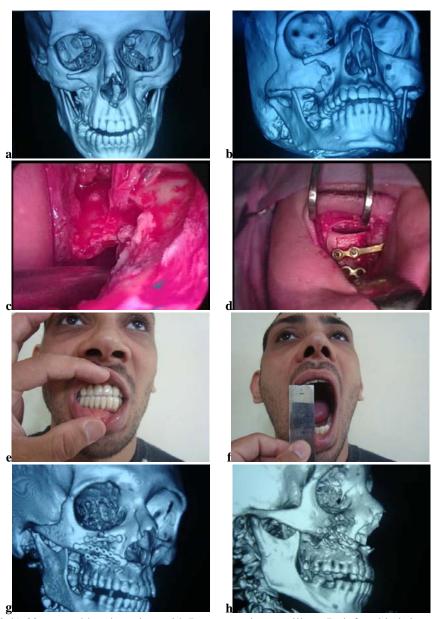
(a& b) 32 years old male patient with Rt zygomatico-maxillary, Rt infraorbital rim and Rt orbital floor fractures. Preoperative CT with 3D of the patient show Rt zygomatico-maxillary, Rt infraorbital rim and Rt orbital floor (c & d) intraoperative infraorbital rim fracture, infraorbital nerve and vessels appear, fixation of infraorbital rim with plates, (e & f) 18 Months post operative photography of the patient showing occlusion and moth opening. (g & h) 6 Months post operative 3D CT reconstruction.
